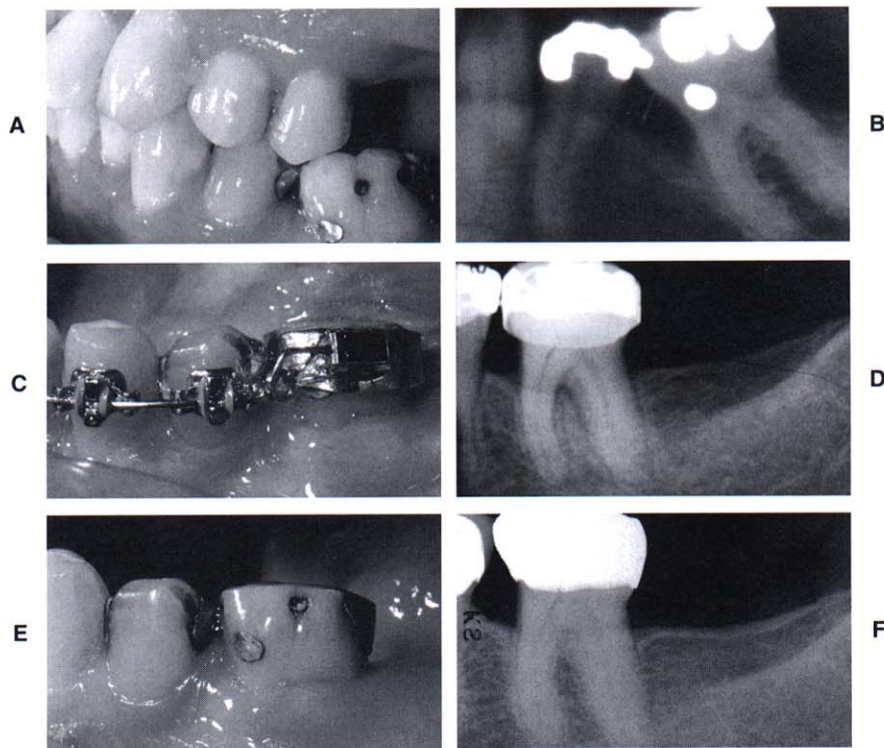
This patient was missing the mandibular left second premolar, and the first molar had tipped mesially (A). A pretreatment periapical radiograph (B) revealed a significant hemiseptal osseous defect on the mesial of the molar. To eliminate the defect, the molar was erupted and the occlusal surface was equilibrated (C). The eruption was stopped when the bone defect was leveled (D). The posttreatment intraoral photograph (E) and periapical radiograph (F) show that the periodontal health had been improved by correcting the hemiseptal defect orthodontically.
